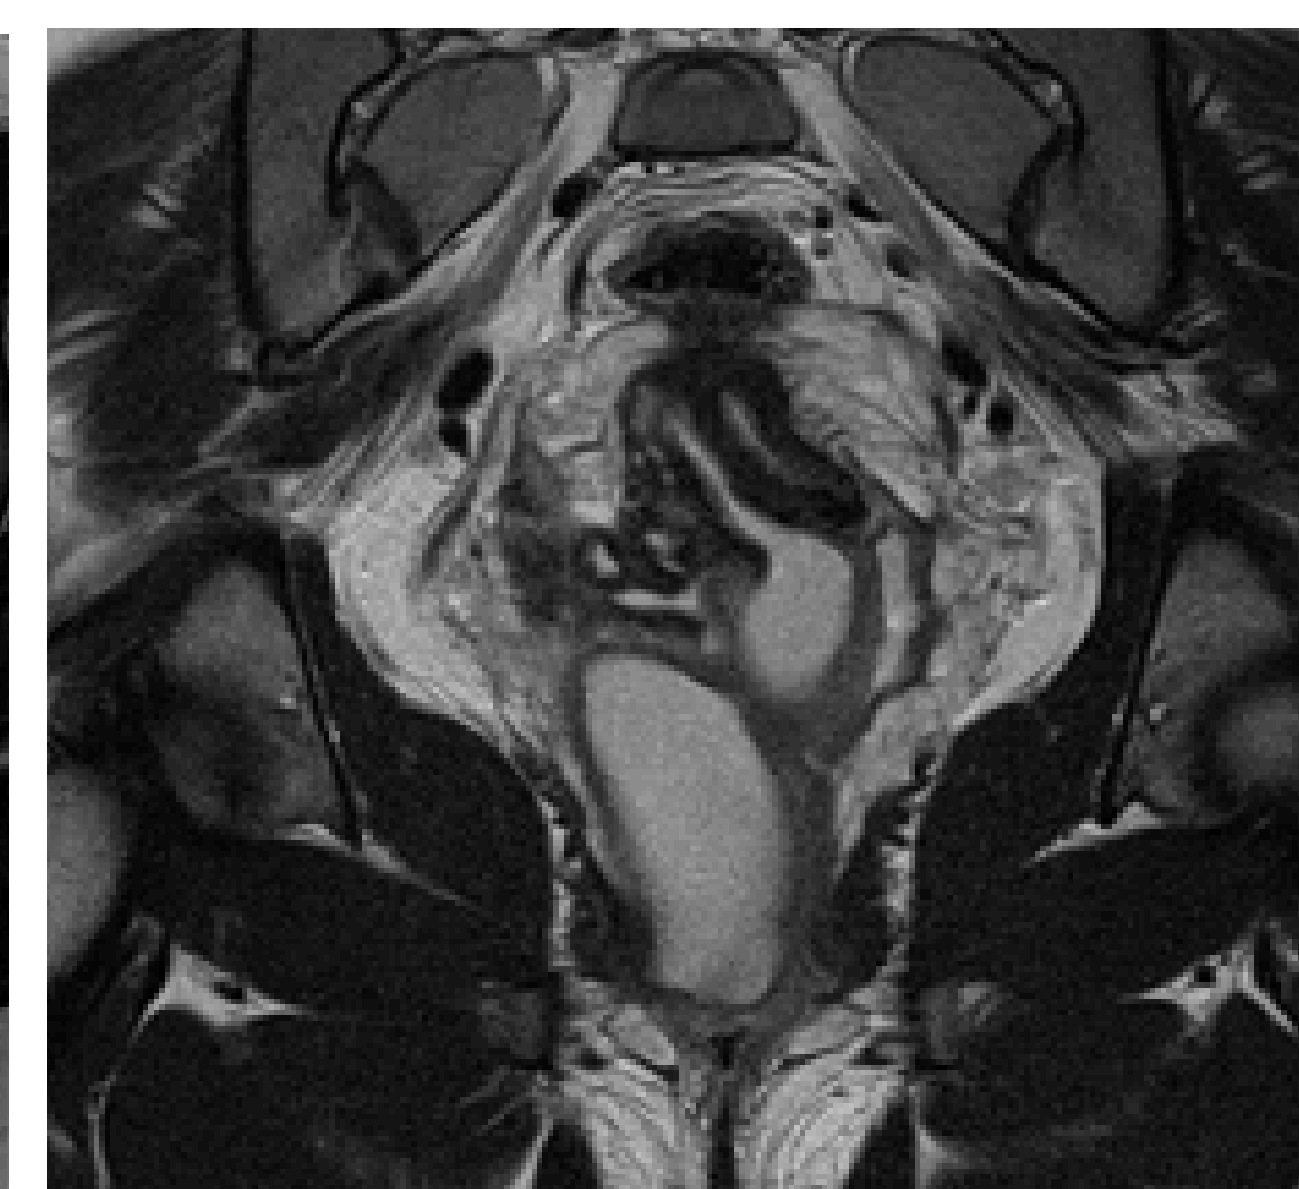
MRI Pelvis. T2 Coronal demonstrating duplication of endocervical cavity.
